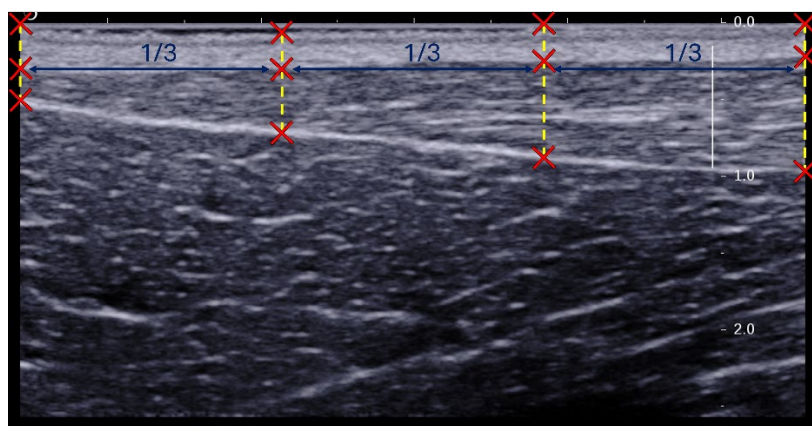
B-mode ultrasound with tissue thickness measurement locations.
